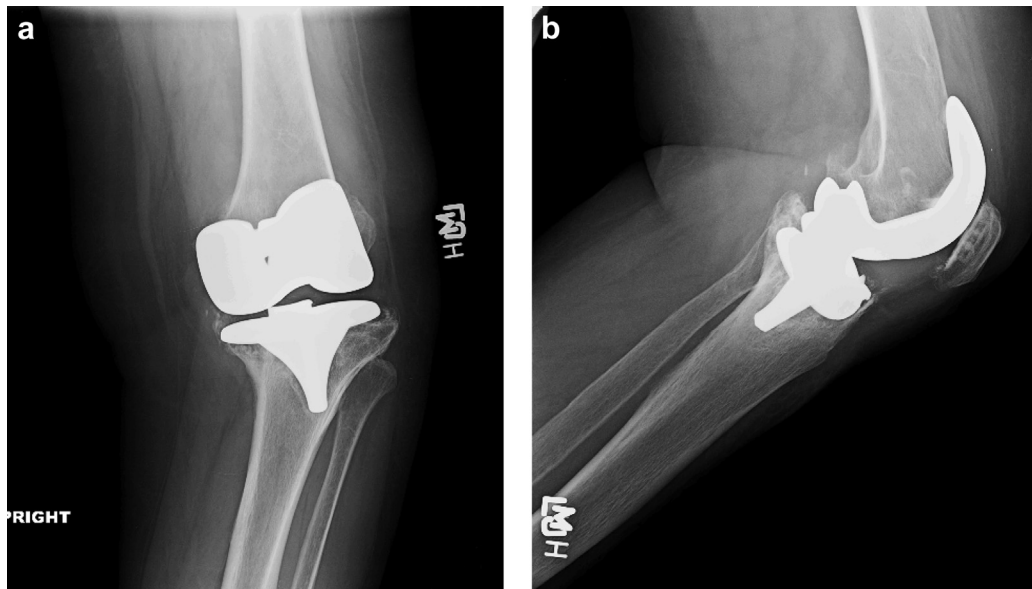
Representative anteroposterior (AP) (a) and lateral (b) knee radiograph demonstrating significant varus collapse of primary tibial base tray with significant metaphyseal bone loss.
